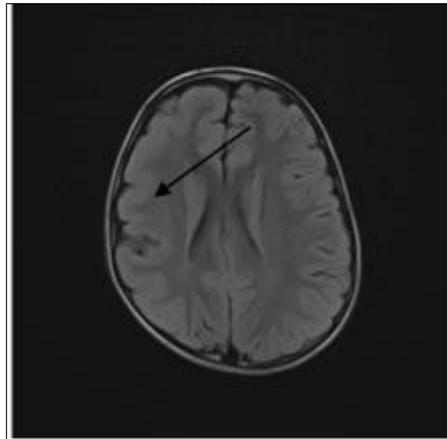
Lissencephaly; FLAIR axial section showing a smooth right hemispheric cortical appearance, with rarefaction of the cortical sulci (arrow), in a 7-year-old boy with delayed height
